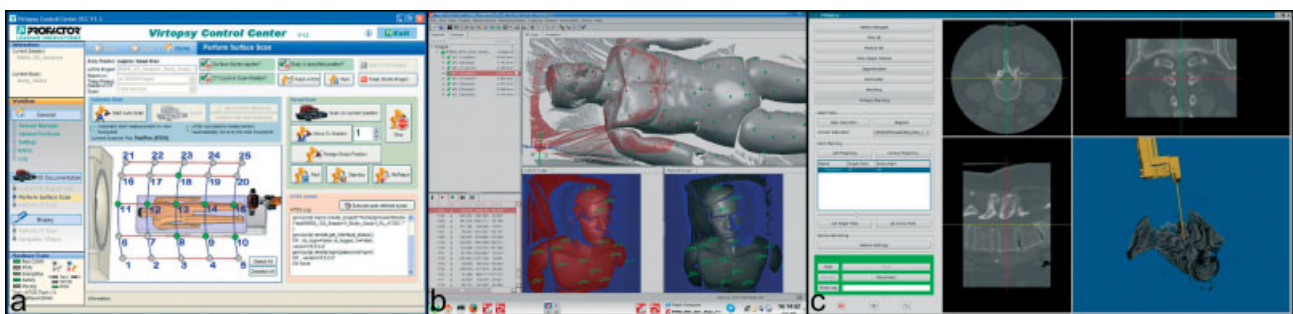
Screenshots of software packages in use. (a) Virtopsy control centre (VCC): selection of scanning positions for surface scan. (b) Screenshot ATOS: surface model composed several single surface scans. (c) Screenshot planning and navigation station: trajectory-planning module with multi-planar reconstruction and volume representation of a CT dataset. Final position of the robot is superimposed
